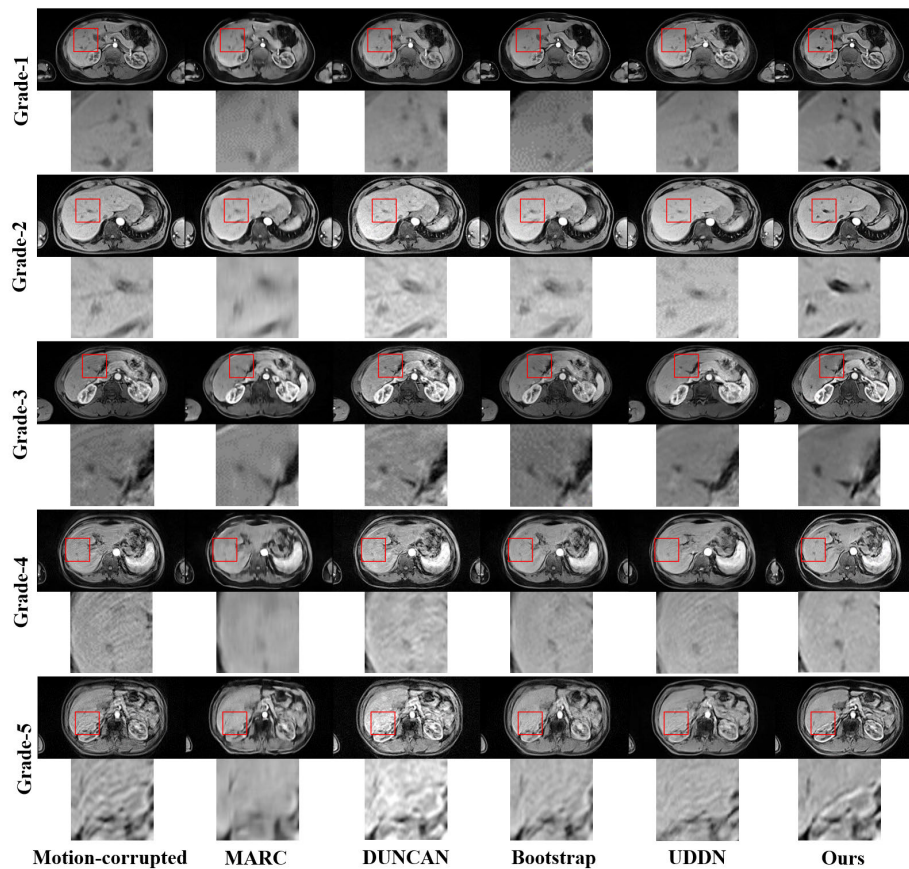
Motion correction results of clinical gadoxetic acid-enhanced human liver MRI using various methods.
